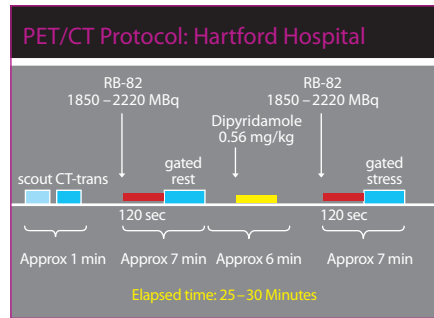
PET/CT protocol for myocardial perfusion imaging with ^{82}Rb at Hartford Hospital in Hartford, Connecticut
